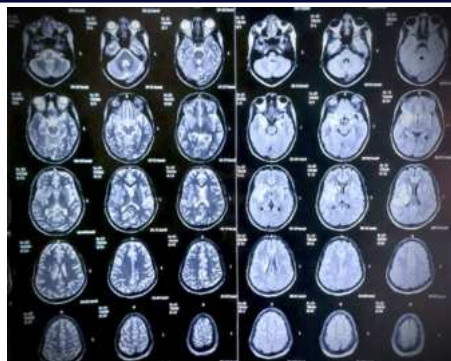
Axial T2 (right) and FLAIR (left) images of the 16-year-old girl showed well defined hyperintensities in right insular cortex, caudate and lentiform nuclei. Additionally sulcal spaces are more prominent than expected for age, suggesting chronic microvascular insults.
